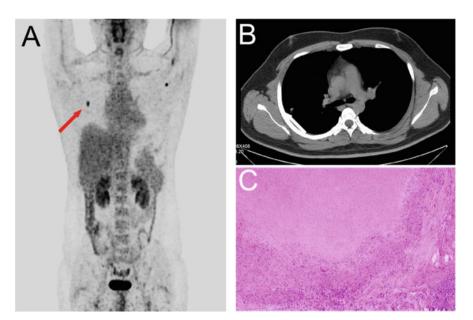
(a) ¹⁸F-FDG PET/CT images demonstrated a 12.9-mm*7.7-mm mass of intensive FDG uptake in the right middle lung (*red arrow*) with SUVmax = 5.33. (b) Diagnostic CT image showed a 13-mm*6-mm nodule in the lateral segment of the right middle lung. (c) Routine pathology of the mass revealed "chronic granulomatous inflammation"
